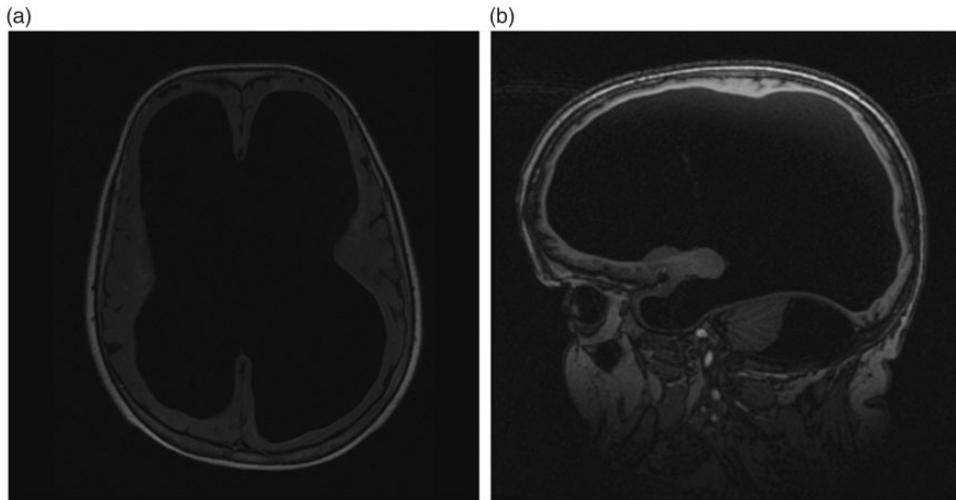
(a) An axial fluid-attenuated inversion recovery image and b) sagittal T1-weighted image show marked ventricular expansion and brain cortical thinning
